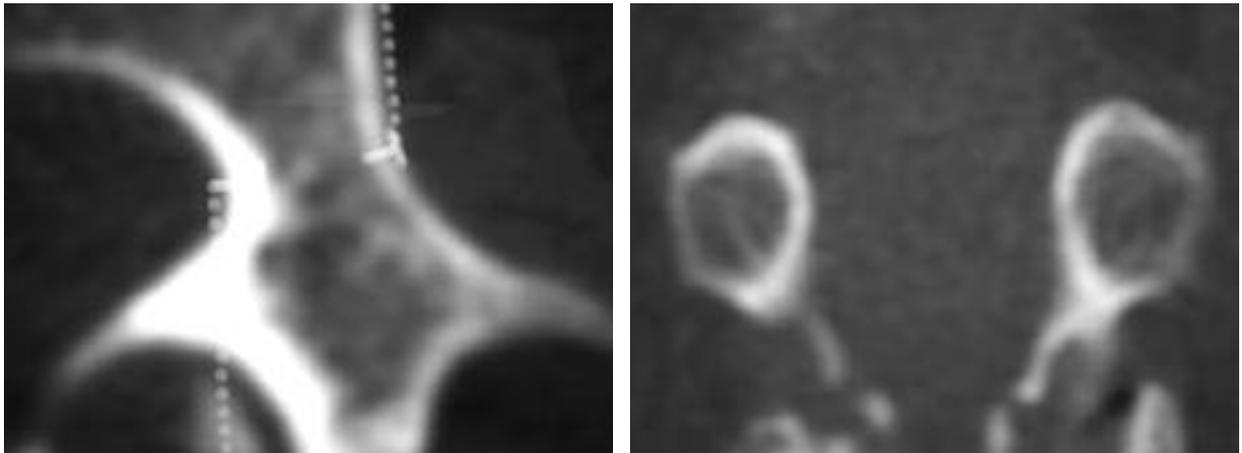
a. Axial pedicle CT and b. Coronal CT were showing the both left and right pedicles, medial wall is thicker than the lateral wall.
